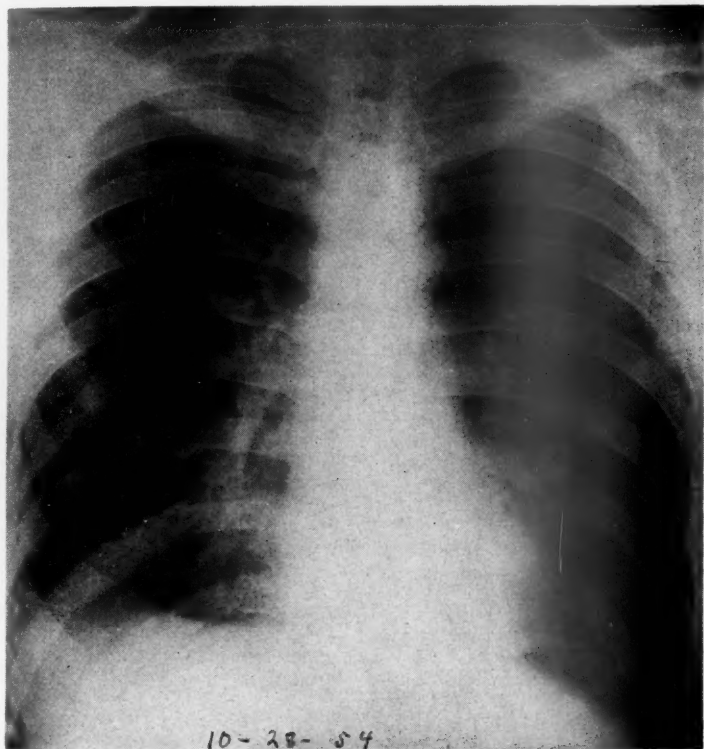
Chest x-ray on October 25, 1954, showing marked clearing of right base after seven months of intermittent treatment.
